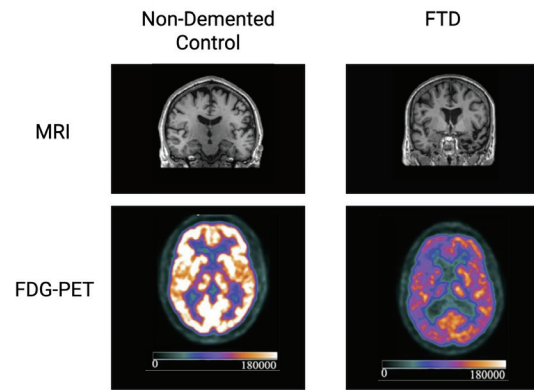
Comparison of MRI and FDG-PET Scans for Non-Demented Control and FTD Brain. The images captured using an MRI scan demonstrate how a brain looks after it has experienced atrophy due to FTD, while the images captured using an FDG-PET scan show the metabolic levels between the non-demented control and the individual with FTD. The color scale located at the bottom of the FDG-PET images indicates that the colors closer to 180000 convey a higher metabolic activity, whereas the colors closer to 0 imply a lower metabolic activity. Adapted from Chouliaras and O'Brien, and Ward *et al.* Created using Biorender.
